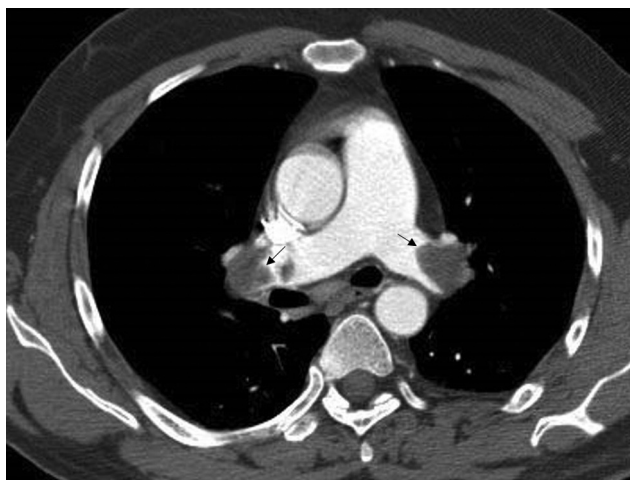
A 26-year-old man presented with shortness of breath, 2 days after receiving the second dose of ChAdOx1 vaccine. Computed tomography (CT) pulmonary angiography axial image shows filling defect in the right and left pulmonary arteries (black arrows), suggestive of pulmonary thromboembolism.
